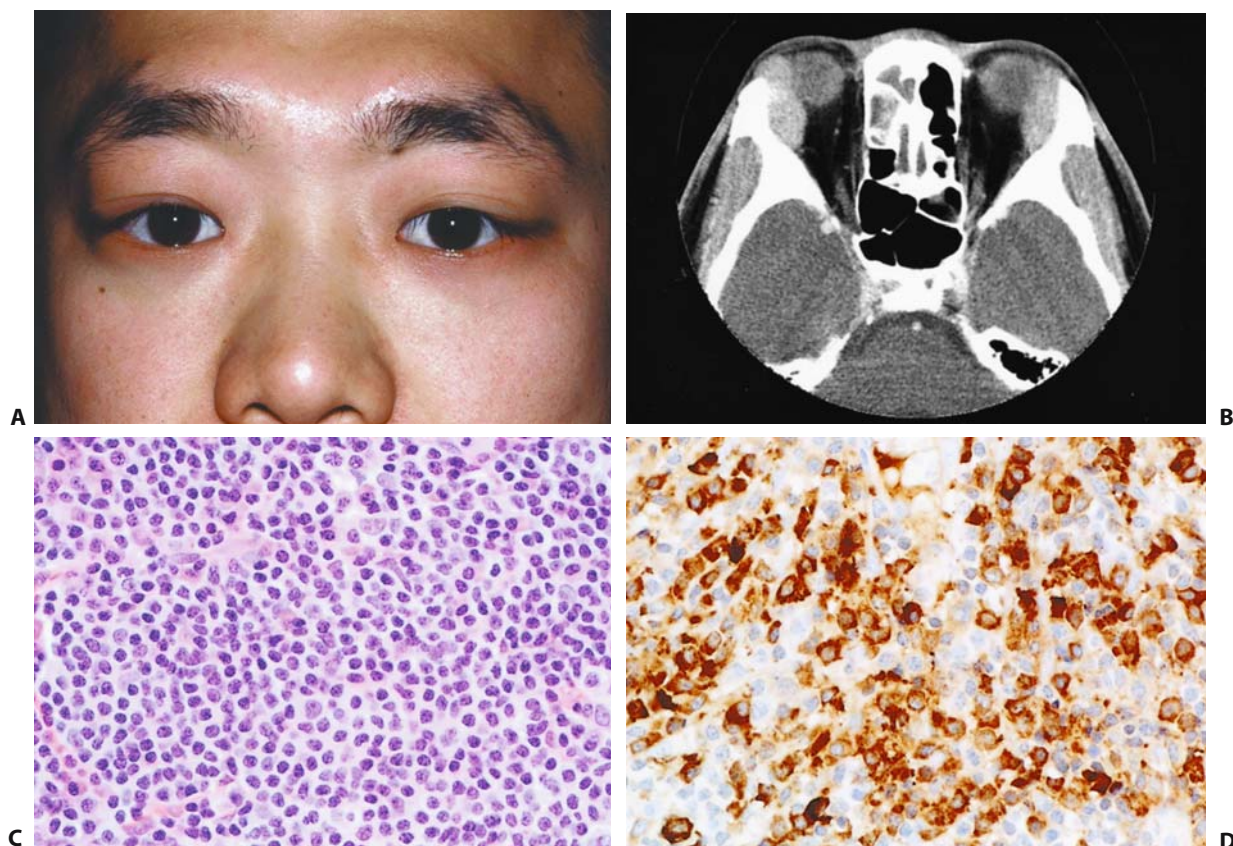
Lymphoma in a 26-year-old man with bilateral, non-tender enlargement of the lacrimal glands. (A) Facial photograph. (B) Axial CT image shows diffuse enlargement of the lacrimal glands that is smooth in outline, of homogeneous density, and molds around the eyeball. (C) Low-grade, marginal zone B-cell lymphoma
